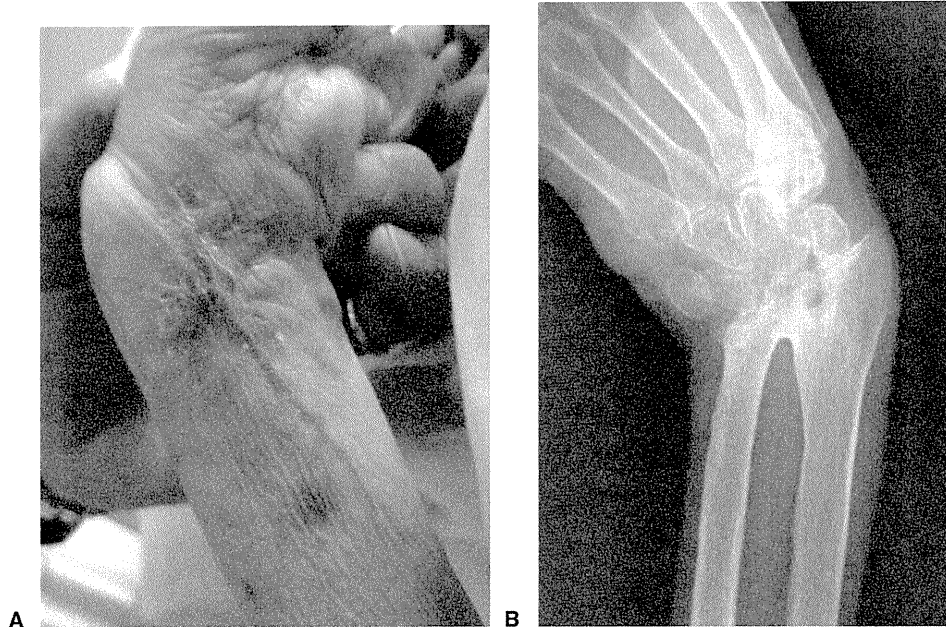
Images of the left forearm after administration of corticosteroids A Full epithelialization of the ulcer. B X-ray shows fusion of the distal radioulnar joint and radiocarpal joint.
